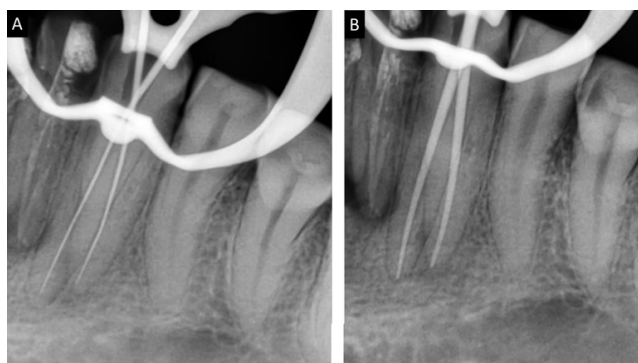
Intra-operative radiographs of A: Working length determination and B: Master cone selection
